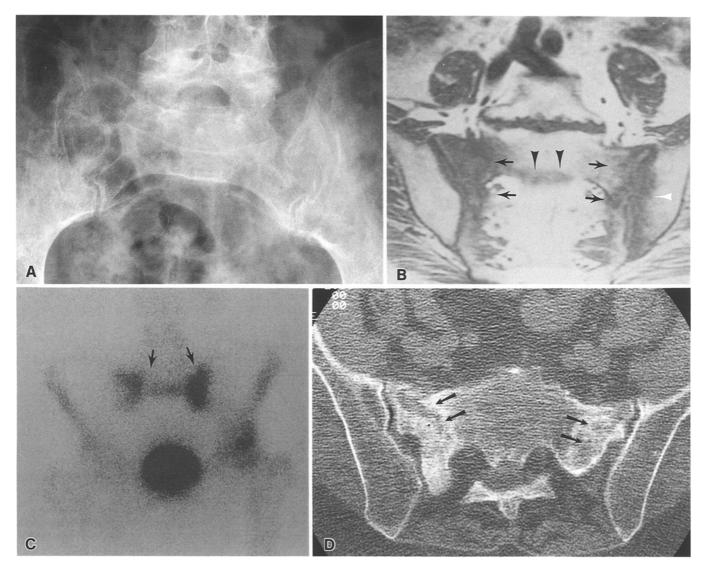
Sacral insufficiency fracture in a patient with low back pain and no history of primary tumor or trauma. A Plain radiograph of the sacrum demonstrates osteopenia. Overlying bowel gas precludes certain diagnosis of a fracture. B Coronal T₁-weighted MR image demonstrates bands of decreased signal paralleling both sacroiliac joints (black arrows) and extending across the body of the sacrum (arrowheads). Decreased signal intensity
